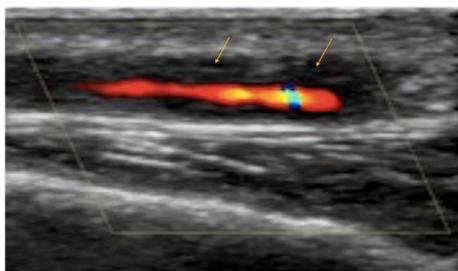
Color Doppler longitudinal US image shows a circumferential non-compressible hypoechoic wall oedema (arrowhead) of the superficial temporal artery, known as "Halo" sign.
